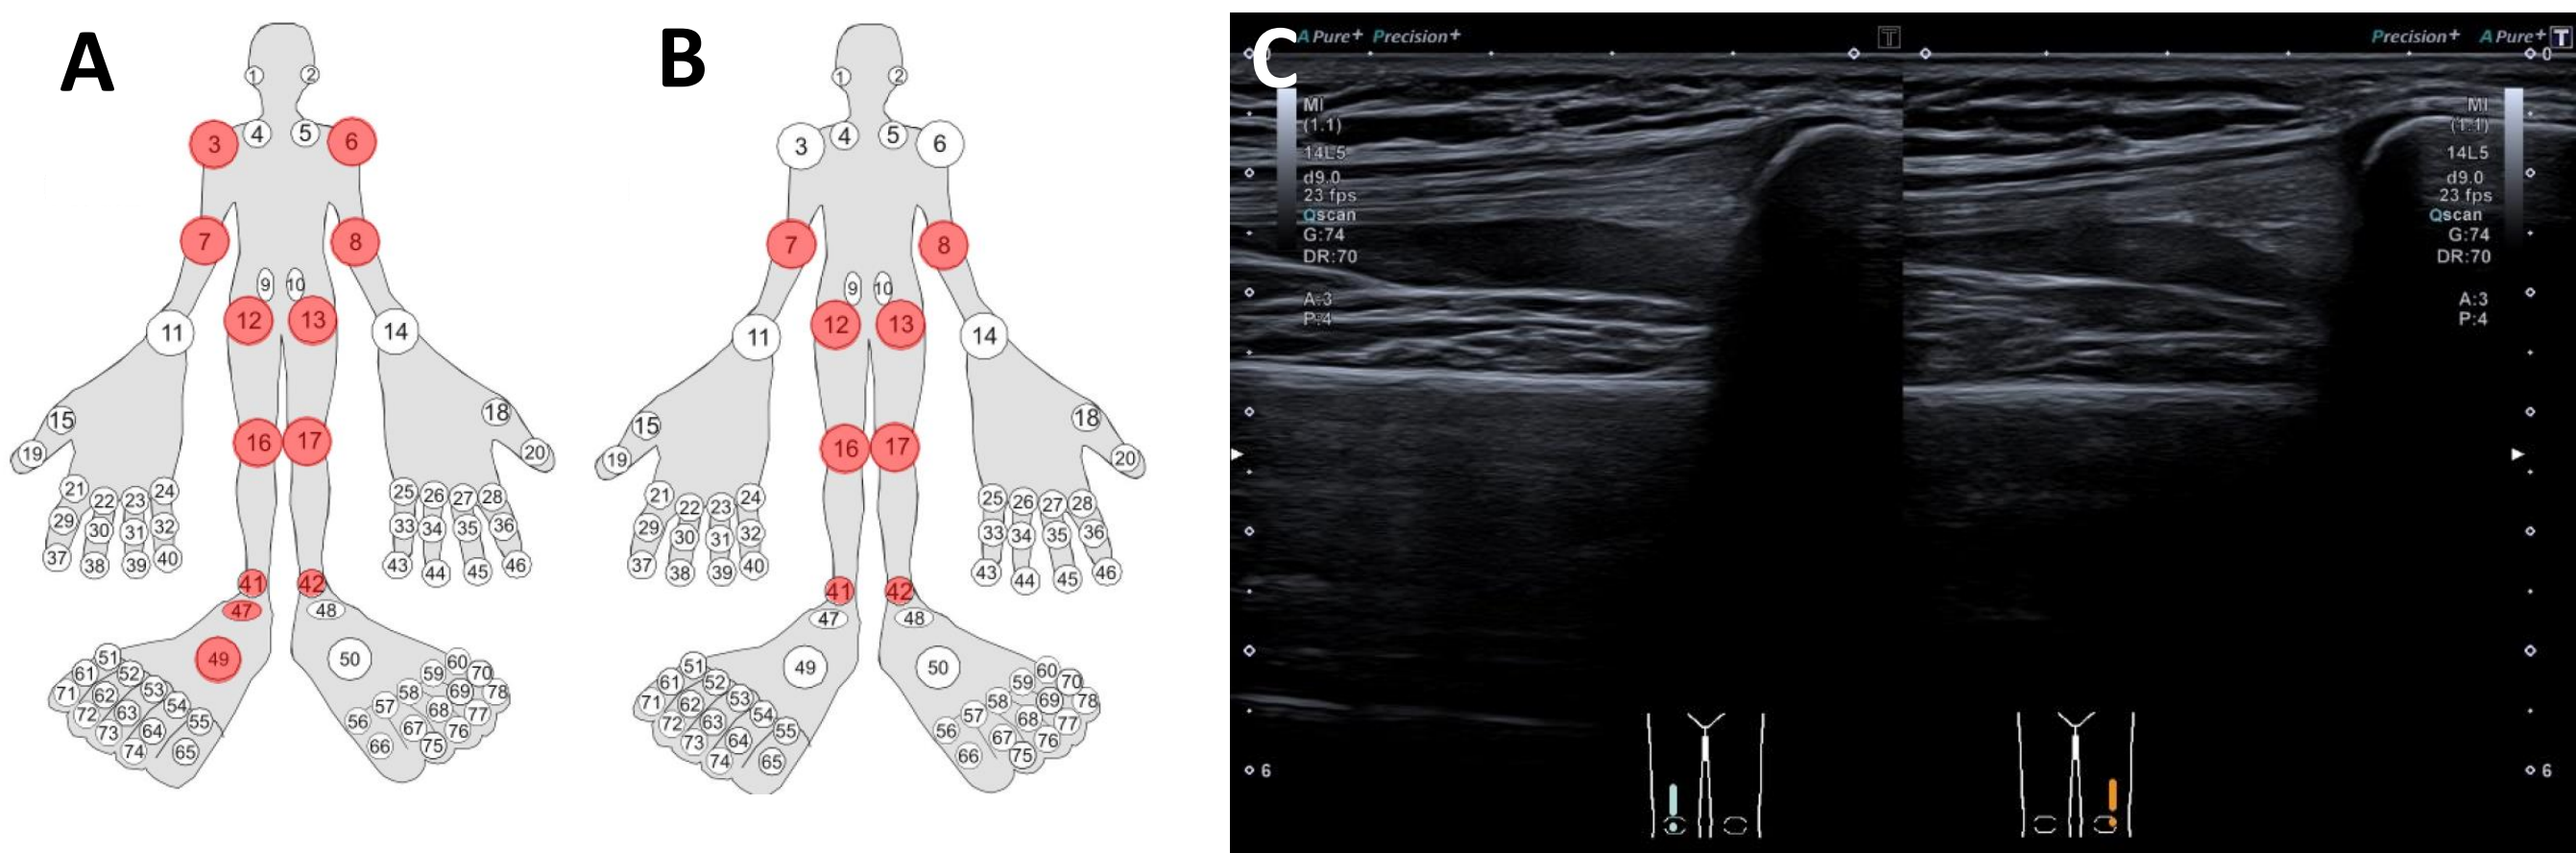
Joint involvement of patients. Ever affected joints of older sister (A) and younger brother (B) throughout disease is shown in red. (C) Ultrasound of both knees in female patient showing suprapatellar effusions.
